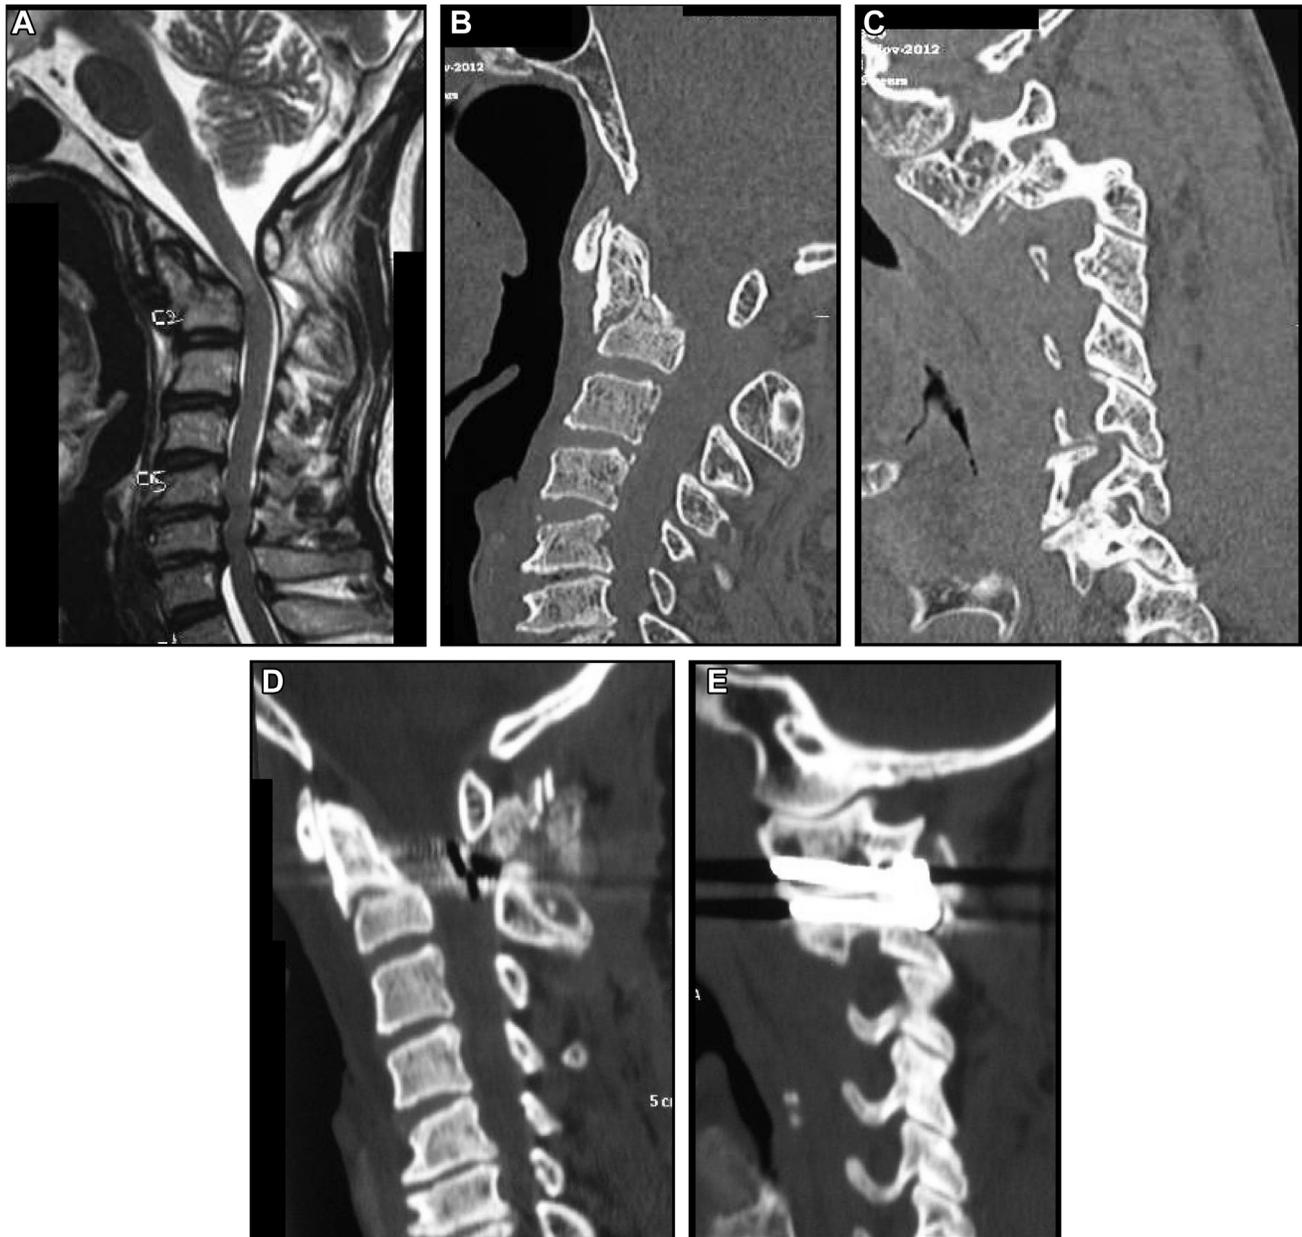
Images of a 46-year-old male patient with a chronic odontoid fracture. (A) T2-weighted magnetic resonance imaging showing the type III odontoid fracture with anterior displacement (type A1) of the fractured fragments. (B) Sagittal computed tomographic scan showing the type III
